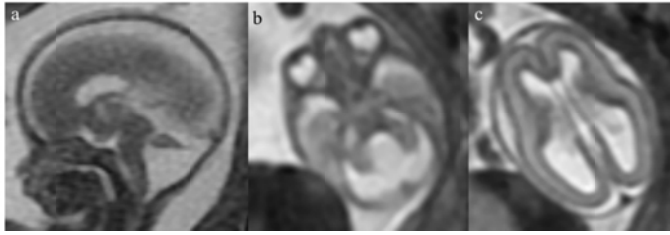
A case of disagreement between ultrasound and outcome reference data with the correct diagnosis being made on in utero MR imaging. The fetus was recruited into the MERIDIAN study from ultrasonography on the basis of a Dandy-Walker malformation and ventriculomegaly and in utero MR imaging was performed at 21 weeks gestational age. There is severe hypoplasia of the cerebellar vermis and mild increased volume of the posterior fossa present on the sagittal and axial iuMR images (4a and 4b) in keeping with a Dandy-Walker malformation. Mild ventriculomegaly was confirmed on the axial image (4c) but there is also hypoplasia of the corpus callosum (arrowed on 4a and 4c and confirmed on autopsy).
